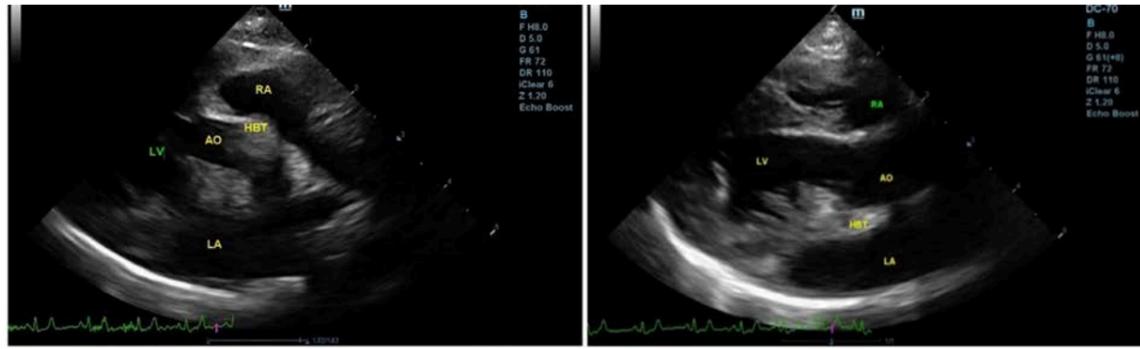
Results of echocardiogram examination prior to the treatment showed cardiac mass in the left atrium at the heart base which led to diagnosis of heart base tumor
